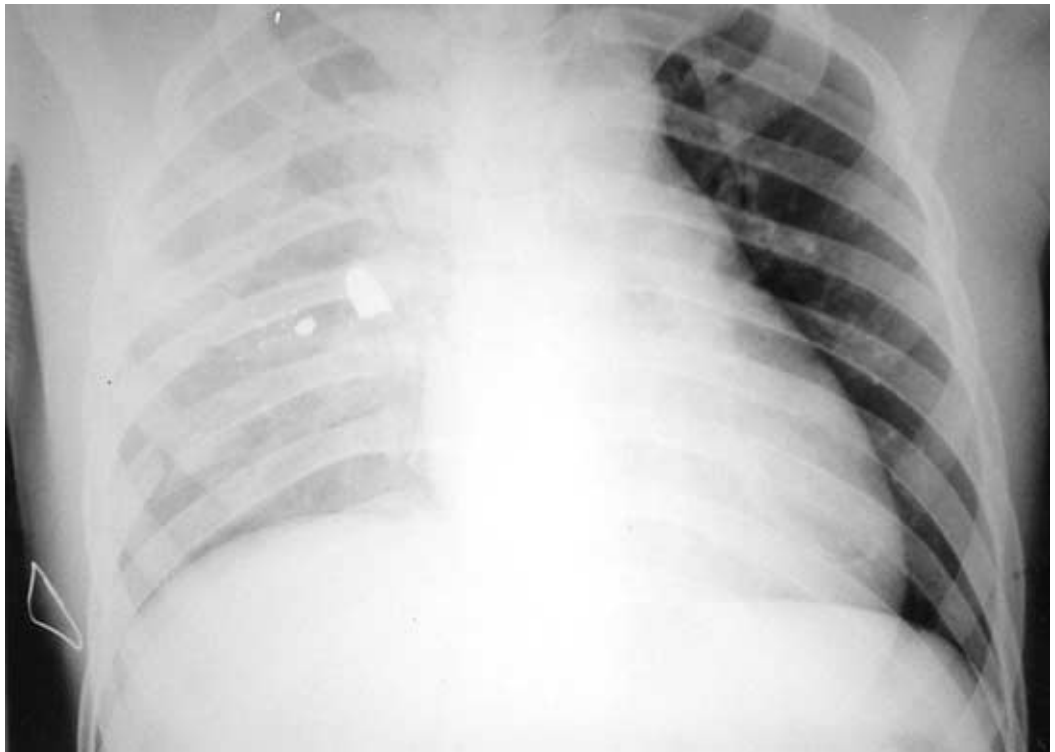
Chest X-ray with radio-opaque marker visible over the right lower chest. Note also the retained bullet.
